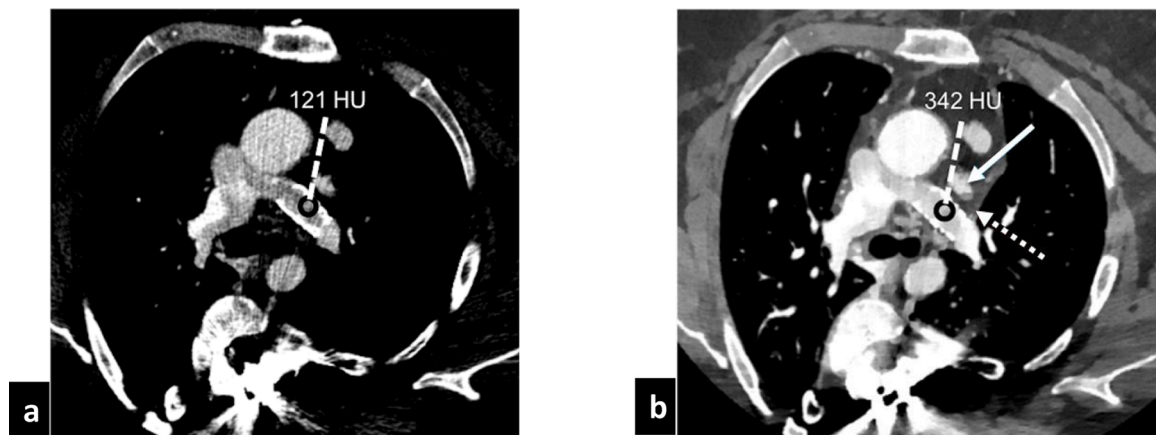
Contrast boost by low keV VMI. A 32-year-old female, with a history of tricuspid atresia, status post left BT shunt in the newborn period, status post classic Fontan followed by fenestrated Fontan and subsequent left pulmonary artery reconstruction and placement of permanent pacemaker. The patient now presents with acute chest pain. Initial conventional CT image (a) demonstrate very poor opacification of the pulmonary arteries and a suspected filling defect/ embolus within the stented left main pulmonary artery. The low keV VM image (b) from the same exam provides the contrast boost and therefore diagnosis of sluggish flow within left pulmonary artery, secondary to the left superior pulmonary vein occlusion was made (Please note that left superior pulmonary vein is not visualized- consistent with chronic occlusion- Red arrow indicates expected location of left superior pulmonary vein and blue arrow represents a portion of left atrial appendage).
